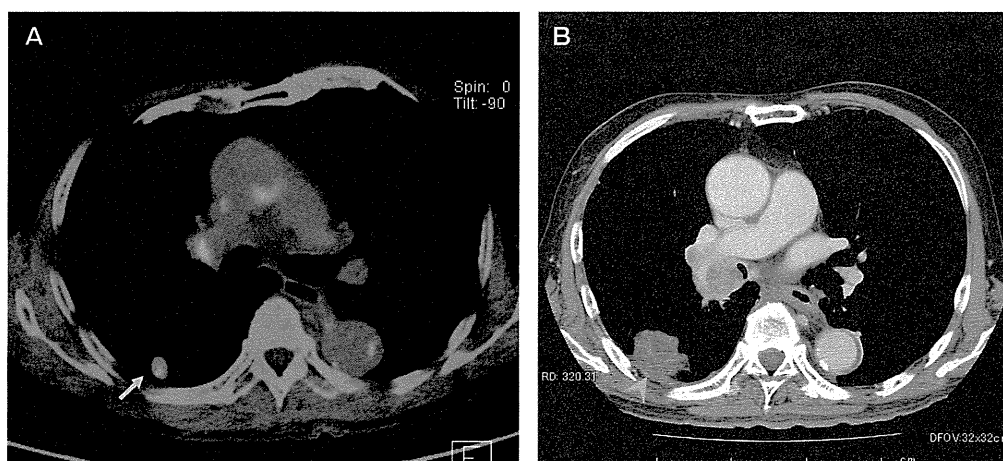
A, Pre-RFA PET/CT of a 77-year-old male with local recurrence. The PET/CT showed primary lung cancer (adenocarcinoma) in the right lower lobe (oblique arrow). This tumor was treated by RFA. The SUV_{max} of the tumor was 3.89; B, The follow-up CT examination was performed 9 months after RFA. The contrast-enhanced CT showed local tumor progression. The ablation zone was circumferentially enlarged. Also, an irregular focus appeared in the ablation zone on contrast-enhanced CT (arrow head).
